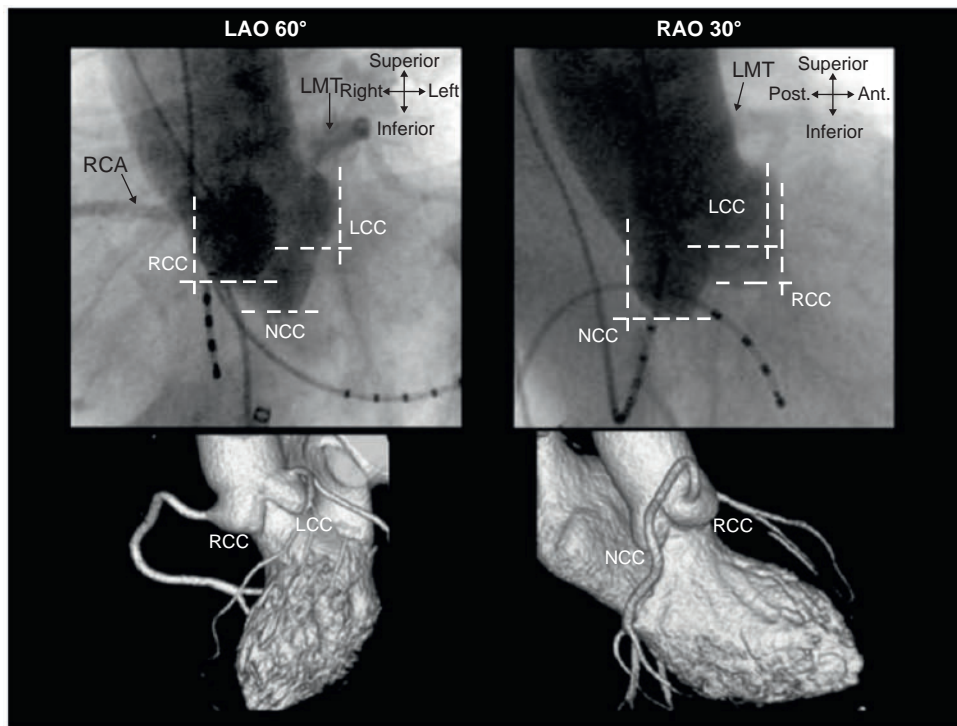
Aortography and Multidetector Computed Tomography of the Aortic Sinuses of Valsalva. Relative positions among each sinus of Valsalva are viewed in the right anterior oblique (RAO) 30-degree, left anterior oblique (LAO) 60-degree projections. Ant., Anterior; LCC, left sinus of Valsalva; LMT, left main trunk; NCC, noncoronary sinus of Valsalva; Post., posterior; RCA, right coronary artery; RCC, right sinus of Valsalva. (From Sasaki T, Hachiya H, Hirao K, et al. Utility of distinctive local electrogram pattern and aortographic anatomical position in catheter manipulation at coronary cusps. *J Cardiovasc Electrophysiol*. 2011;22:521–529.)
